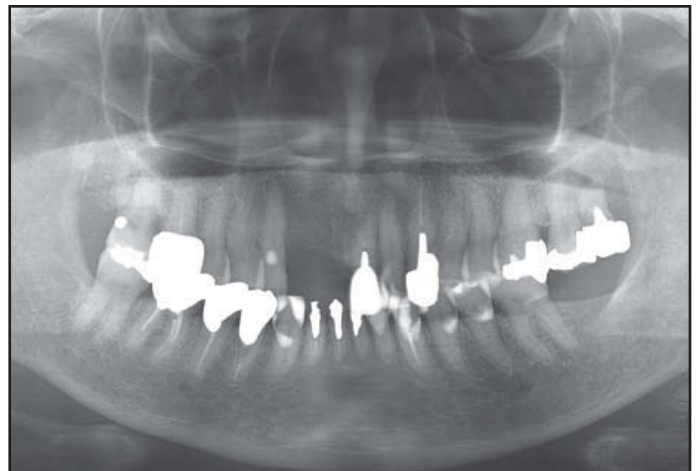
Panoramic radiograph before implant placement in Case 1.
